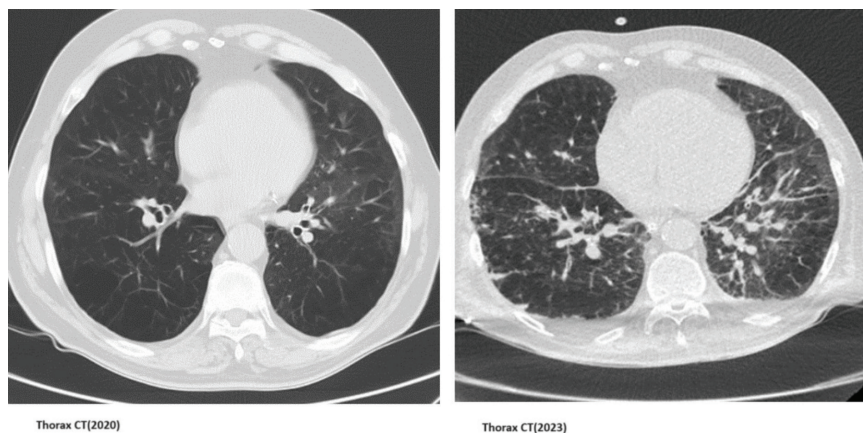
Chest CT showed air trapping, peribronchovascular wall thickening, interlobular septal thickening, and ground glass appearance in both lungs, along with pleural effusion measuring 1 cm in the thickest part in both hemithoraxes
